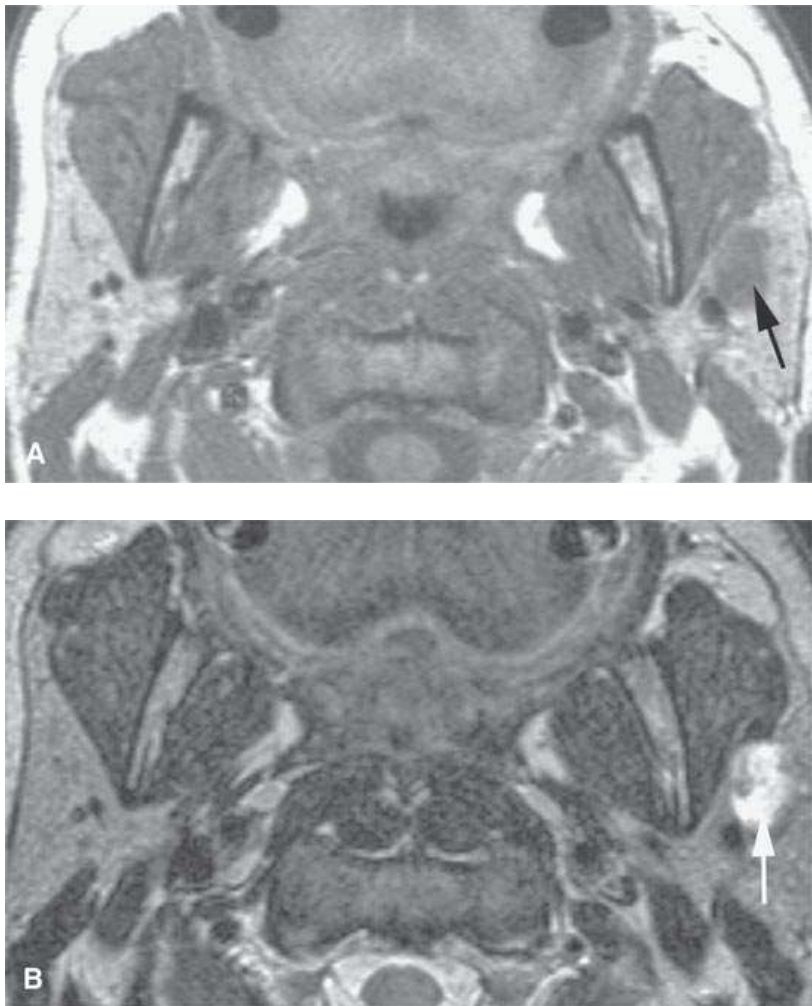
Magnetic resonance imaging of a patient with a benign mixed tumor of the parotid (*arrows*), with the microcystic nature of the tumor better appreciated by the increased signal intensity on the T2-weighted image in (bB) compared with the noncontrast T1-weighted image in (A).
